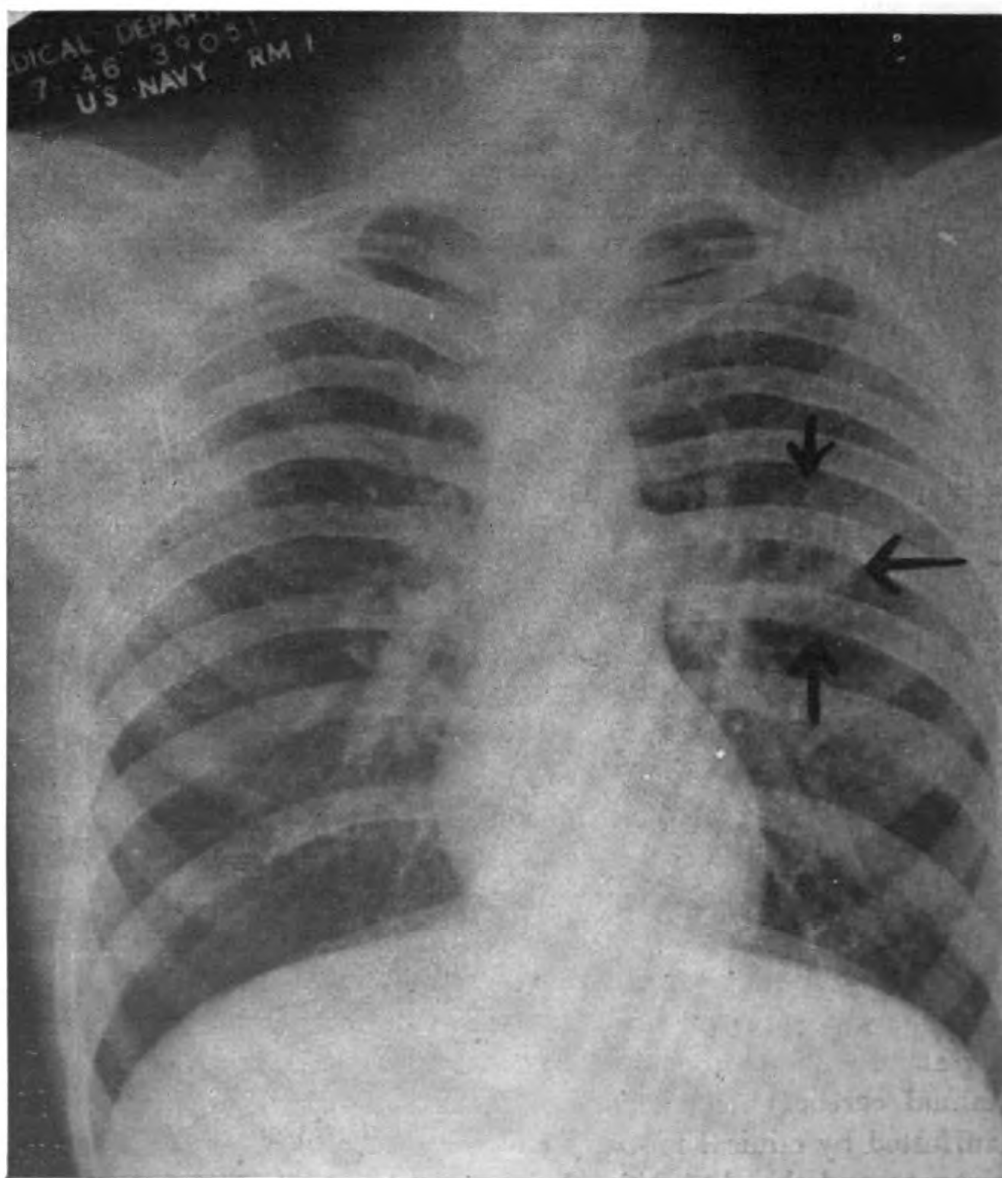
Roentgenogram of 9 January 1946 showing cavitation of left chest anteriorly.
